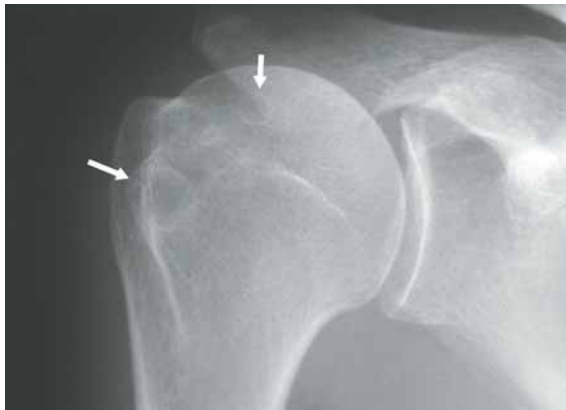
Frontal radiograph of the right shoulder in a 72-year-old woman shows several well-defined rounded osteolytic areas with sclerotic borders (arrows) in the greater tuberosity and subchondral region of the right humeral head compatible with subchondral cysts. There is associated mild narrowing of the glenohumeral joint space and osteoarthritic changes in the acromioclavicular joint.
